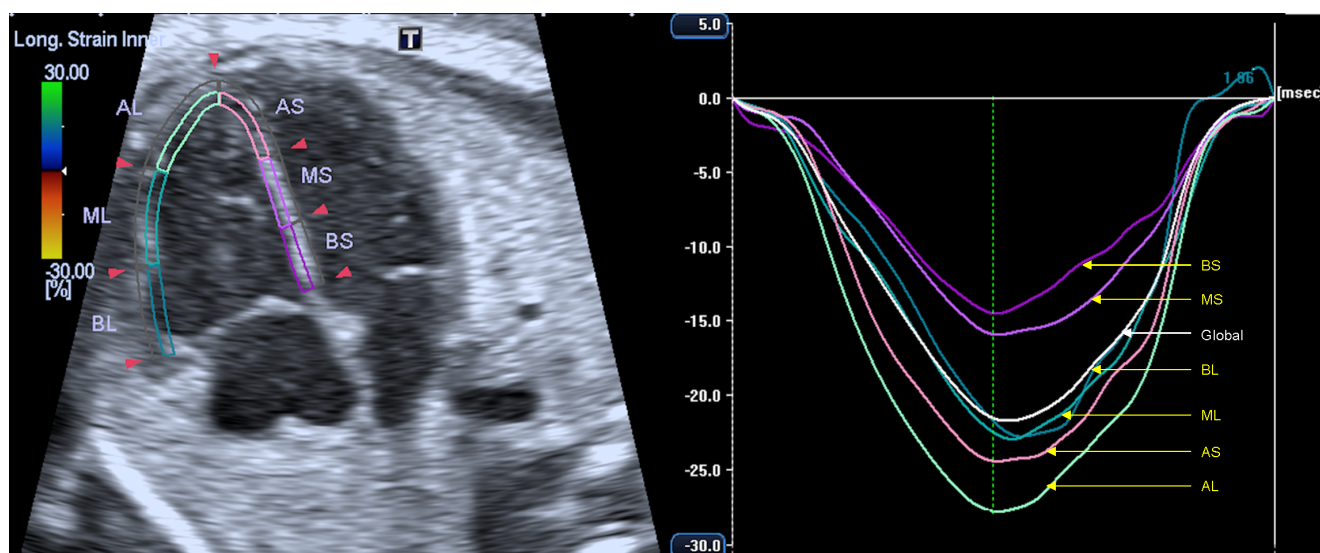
Fetal speckle-tracking echocardiography of right ventricle in normal pregnancy at 36 weeks' gestation. AL, apical lateral; AS, apical septal; BL, basal lateral; BS, basal septal; ML, middle lateral; MS, middle septal.
